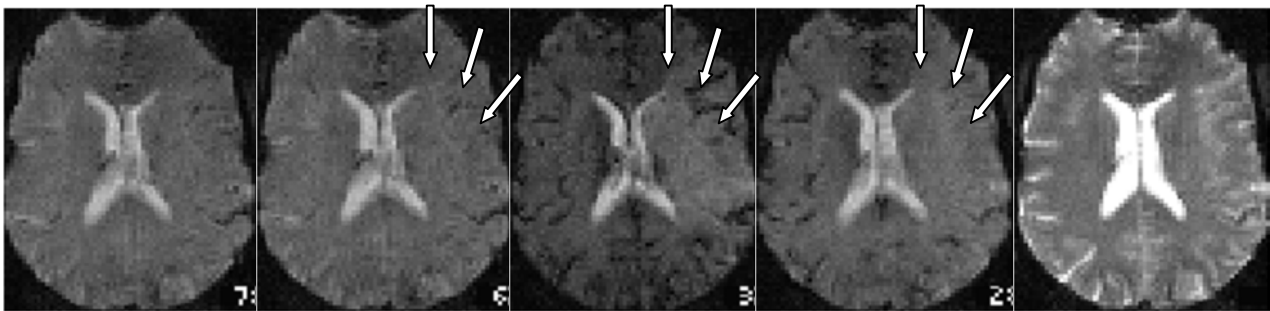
Source images of a dynamic susceptibility contrast enhanced MRI series in a patient with focal cerebral ischemia. Within the ischemic territory the signal decreases much less than in the normal tissue.
